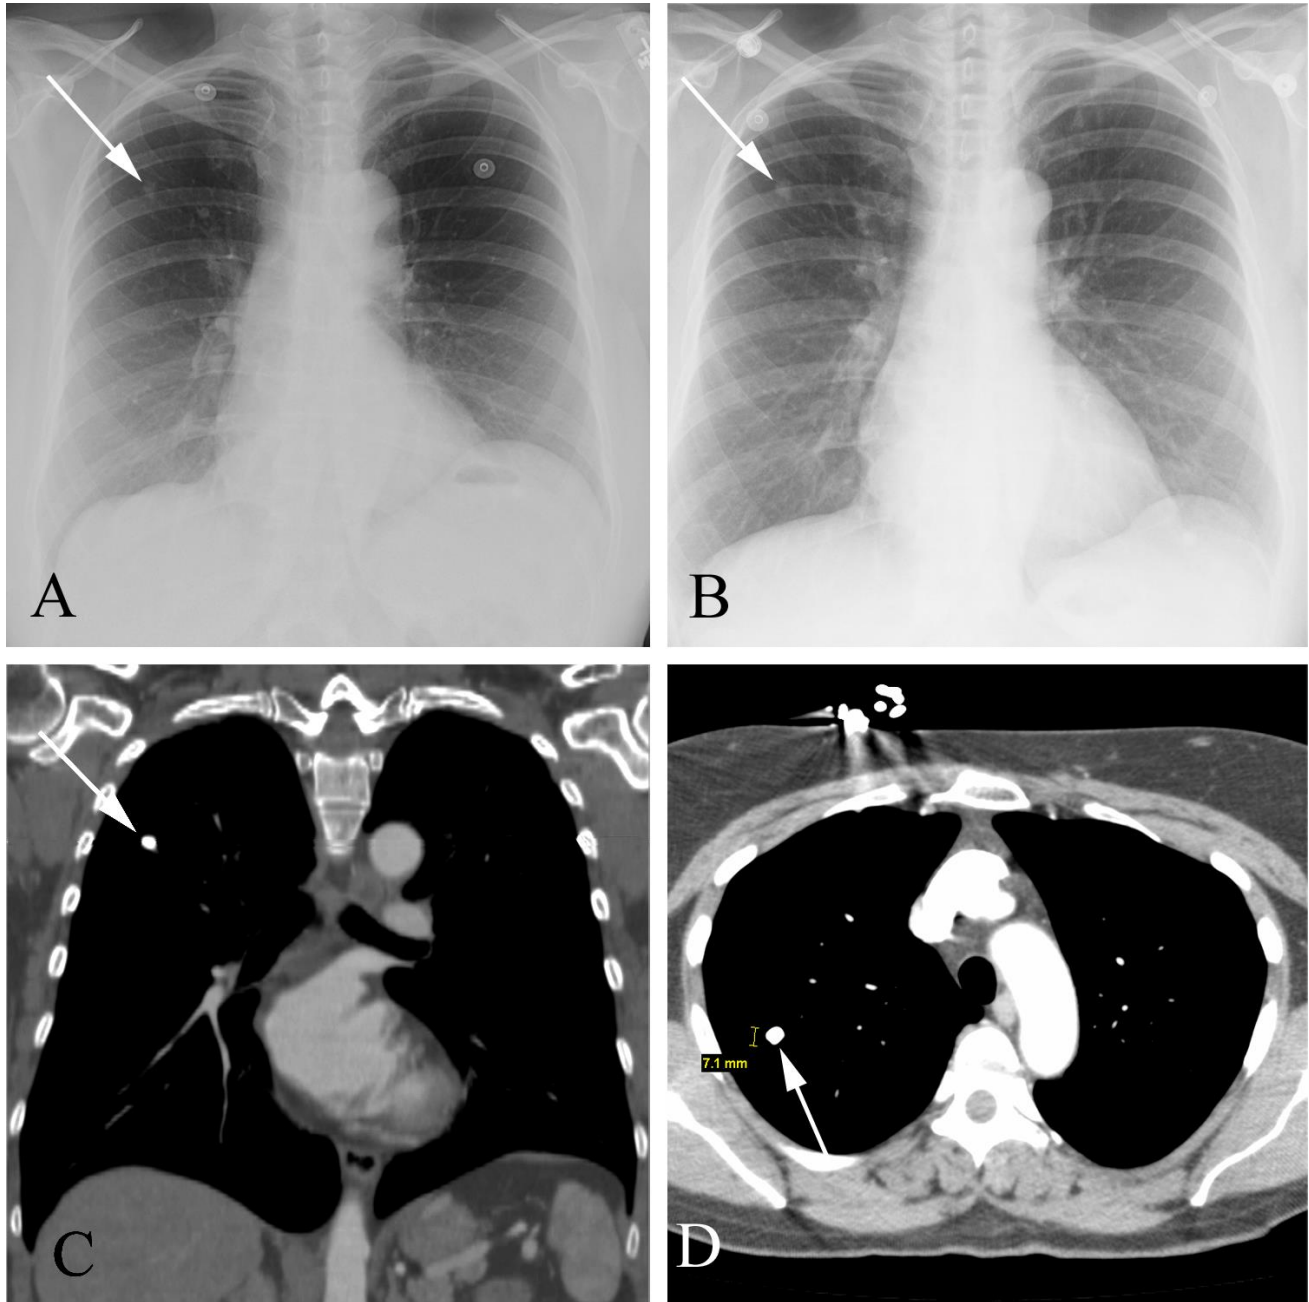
Benign granuloma in a 67 year old woman. A. Baseline PA plain film examination shows a right upper lobe pulmonary nodule. B. Later PA plain film obtained for pain shows an apparent increase in size of the lesion. C. Coronal reconstruction shows a densely calcified lesion (arrow) at the location of the nodule on the chest radiograph. The horizontal localizing line is at the plane of the axial slice. D. Axial CT also shows a densely calcified lesion. No further work-up was required, as the lesion has a completely benign appearance.
